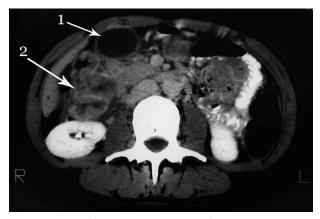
CT scan of the abdomen identifying the gallbladder (arrow 1) and the malignant melanoma metastasis mass in the head of the pancreas (arrow 2).
